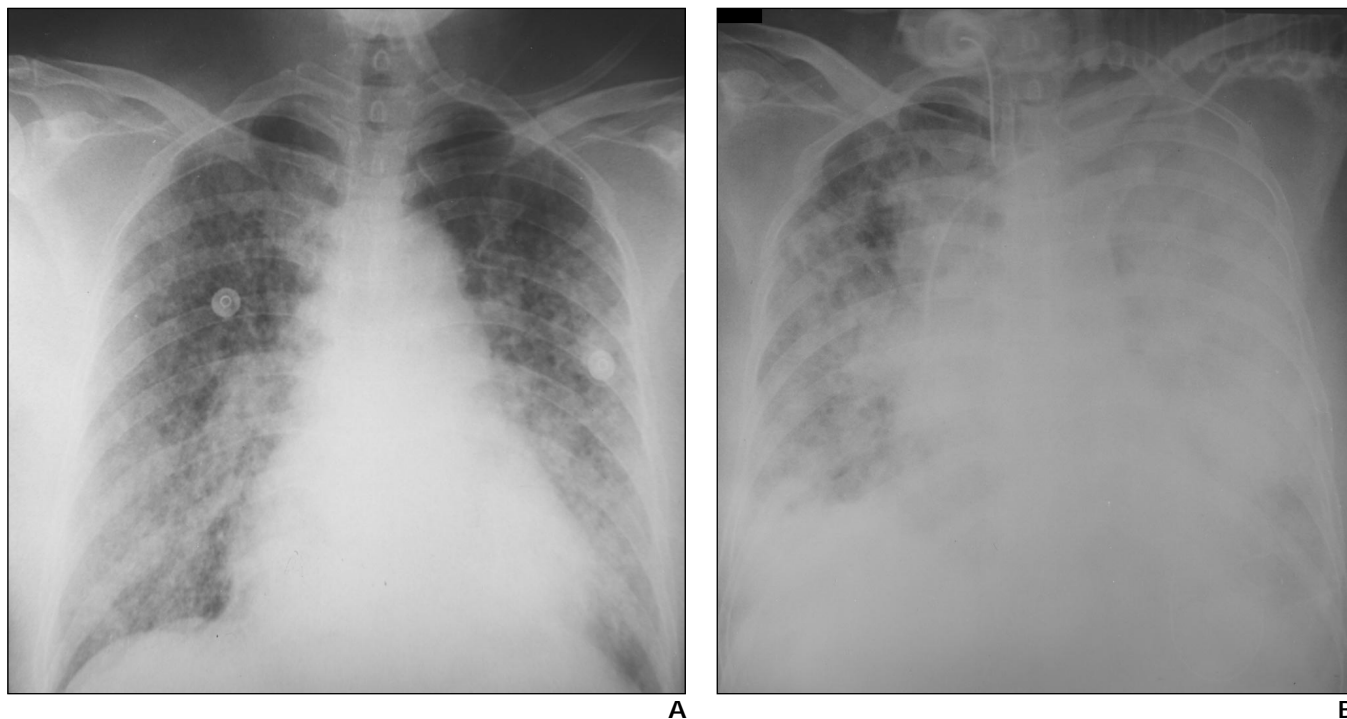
57-year-old woman with all-trans-retinoic acid (ATRA) syndrome, progressing into acute respiratory distress syndrome. A, Chest radiograph 12 days after ATRA treatment shows increased cardiothoracic ratio and increased vascular pedicle width. Poorly defined nodules and ground-glass opacity are noted in entire lung and are considered to be ATRA syndrome. B, Follow-up chest radiograph 42 days after ATRA treatment. Left lung is entirely opacified and coalescent; patchy consolidations are found in right lung, suggesting acute respiratory distress syndrome.
